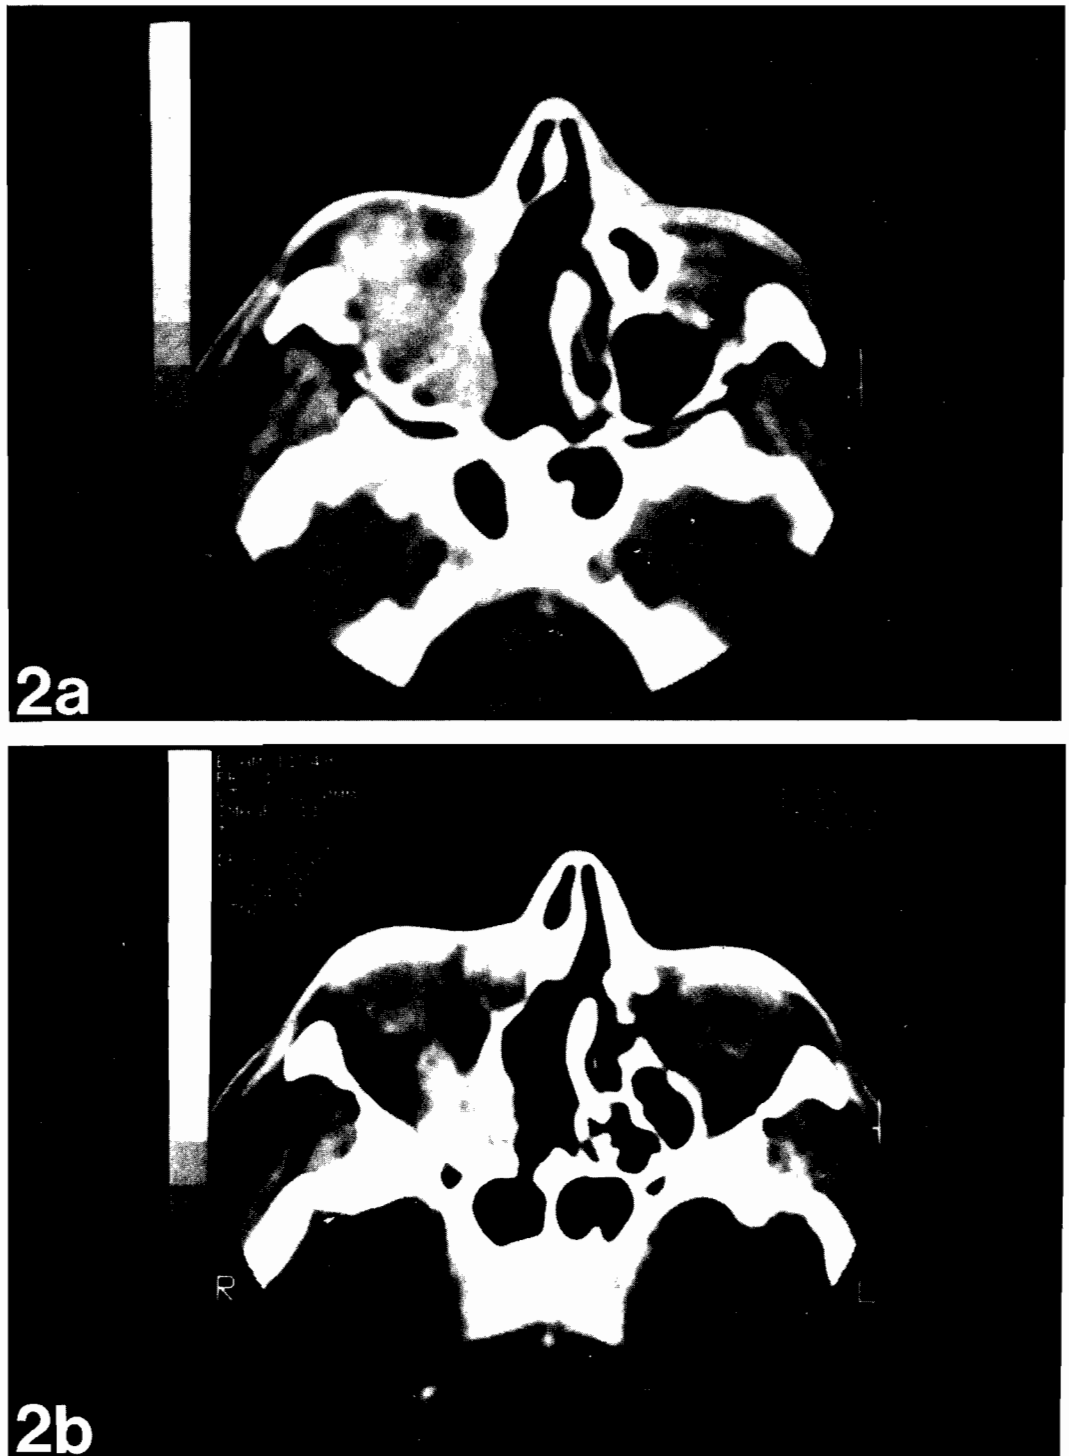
L.L: Preoperative CT scan showing involvement of the right maxillary antrum, ethmoidal labyrinth and nasal fossae, with destruction of the right intersinus nasal wall (a). The infero-medial wall of the right orbit seems involved but no endo-orbital neoplastic tissue can be detected (b).
